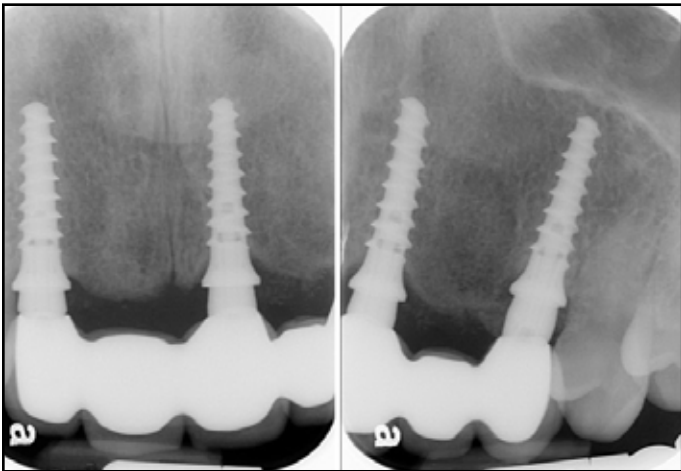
A periapical radiograph in 2 years function reveals stable bone maintenance.
